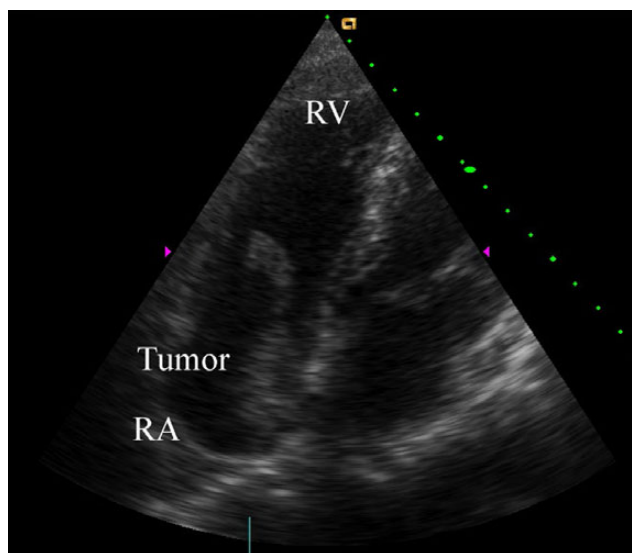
Preoperative transthoracic echocardiography. The right atrial tumor (40 × 20 mm) originated from the interatrial septum. The tumor had a tail-like surface projection, which prolapsed into the right ventricle during diastole. RV, right ventricle; RA, right atrium.
